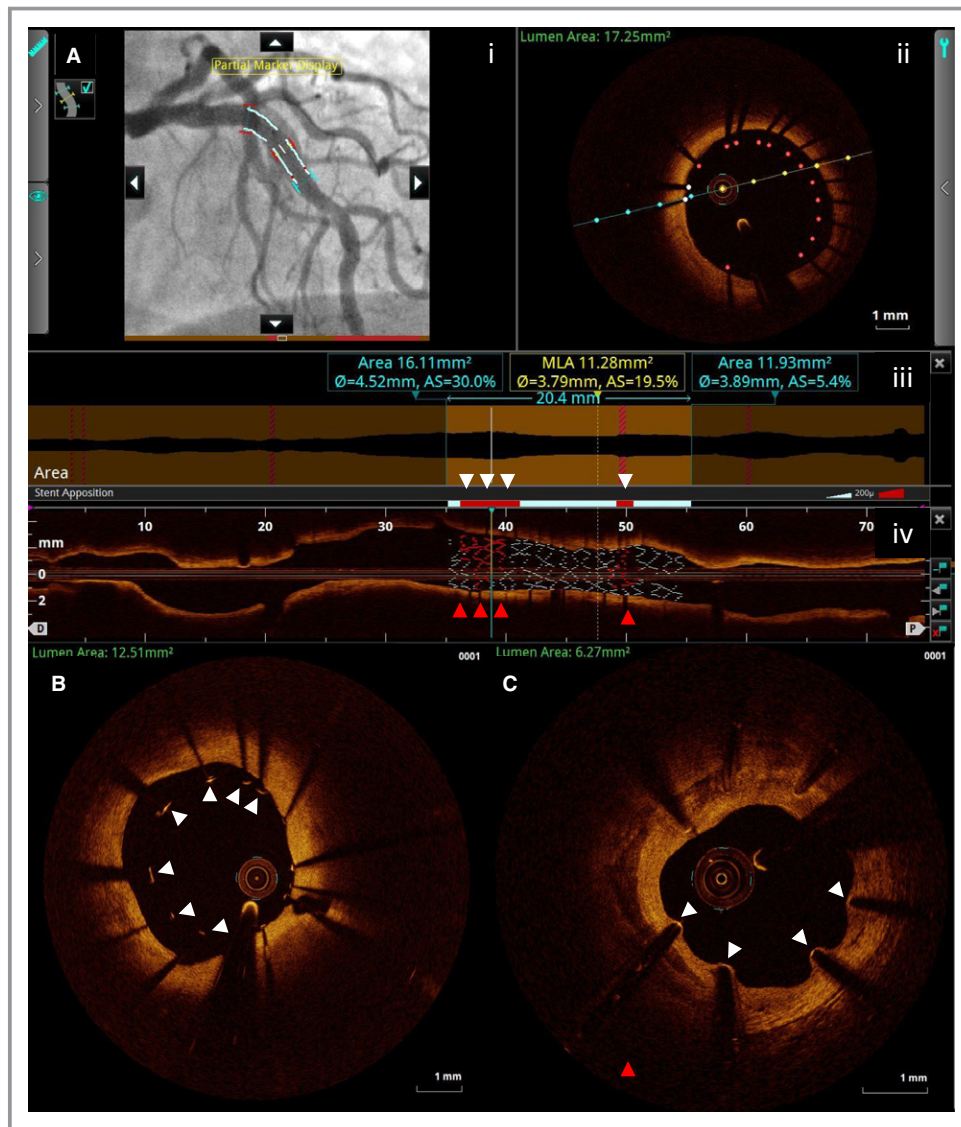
Intravascular imaging assessment of malapposition. A, Optical coherence tomography (OCT) automated detection of malapposition. The high resolution of OCT allows automatic detection of malapposition. Malapposed segments and stent struts are highlighted in red in the angiographic coregistration (i), OCT cross-section (ii), automated measures apposition bar (white arrowheads: red segments of white bar denote malapposed segments) (iii), and rendered stent (red arrowheads: red stent struts of white rendered stent denote malapposed segments) in longitudinal OCT image (iv). B, OCT cross-section showing acute malapposition (white arrowheads). C, OCT cross-section showing neointimal growth toward malapposed struts 15 months after drug-eluting stent implantation. Intravascular ultrasound (D) and OCT (E) coregistered cross-sections from the same patient, showing malapposition (white arrowheads) much more easily visible by OCT because of its superior resolution. AS indicates area stenosis; MLA, minimum lumen area.
